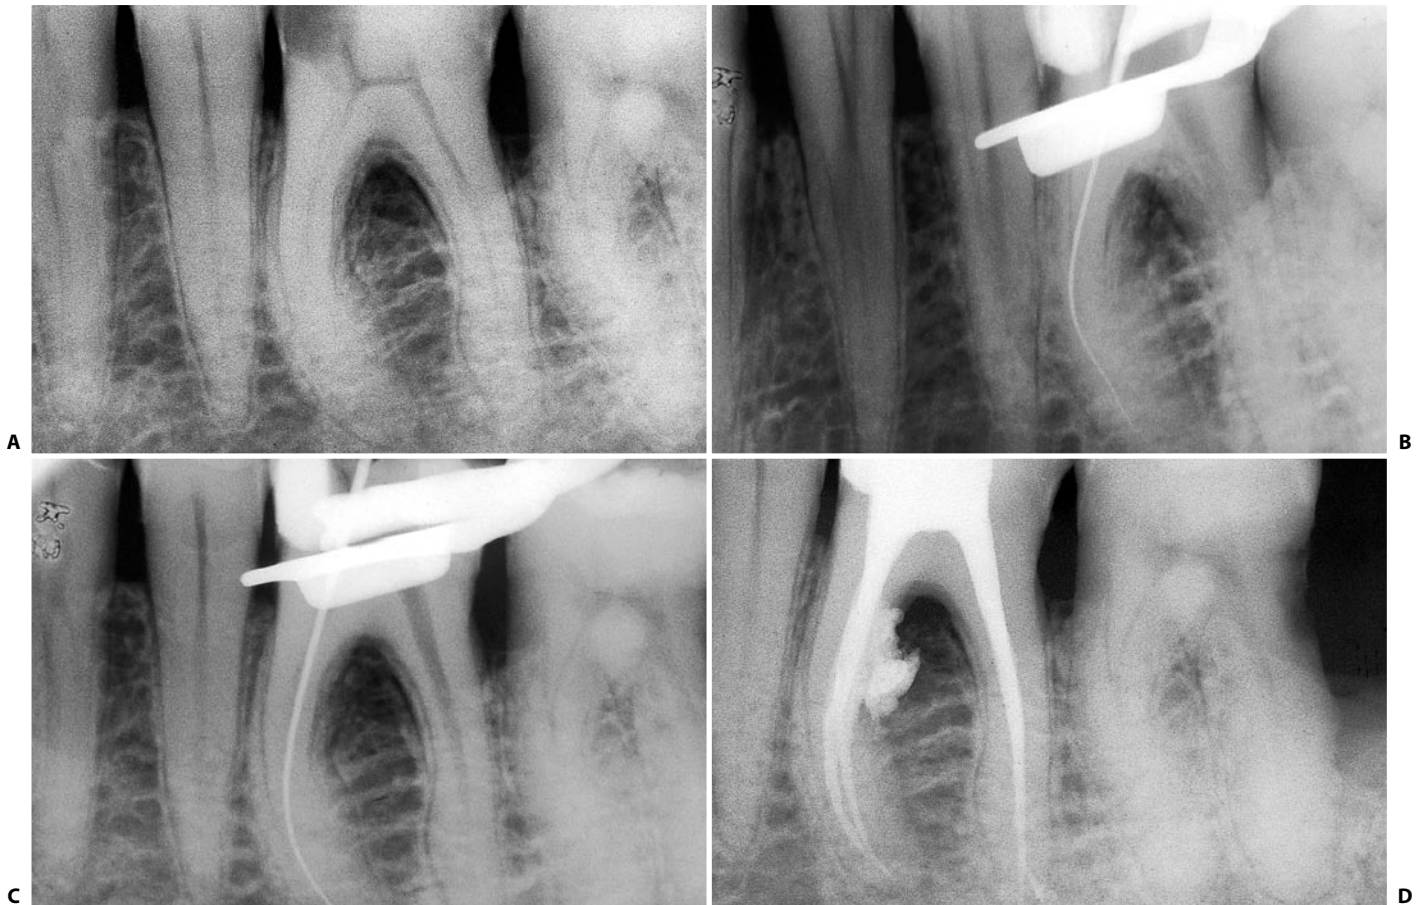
Lack of application of the anticurvature filing method easily leads to stripping in the area of the bifurcation. A. Preoperative radiograph. Note the slight curvature in the middle and coronal thirds of the mesial root of the first molar, and the closeness of the mesial canals to the roof of the bifurcation. B. Intraoperative radiograph of the first instrument at the radiographic terminus of the canal. One can imagine the strong distal inclination of the instrument handle. The radiograph was taken with an excessive apico-coronal inclination of the cone of the X-ray machine. C. Intraoperative radiograph of the last instrument at the radiographic terminus of the canal (# 20 file). Note the distal inclination of the instrument shaft and the extreme closeness of its cutting edges to the bifurcation. Consider that the canal still needs to be enlarged to develop a continuously tapering conical form. D. Postoperative radiograph. The excess material issuing from the area of stripping and the lesion which in the meantime has established itself at the bifurcation, is evident (By kind permission of Dr. G. P.).
